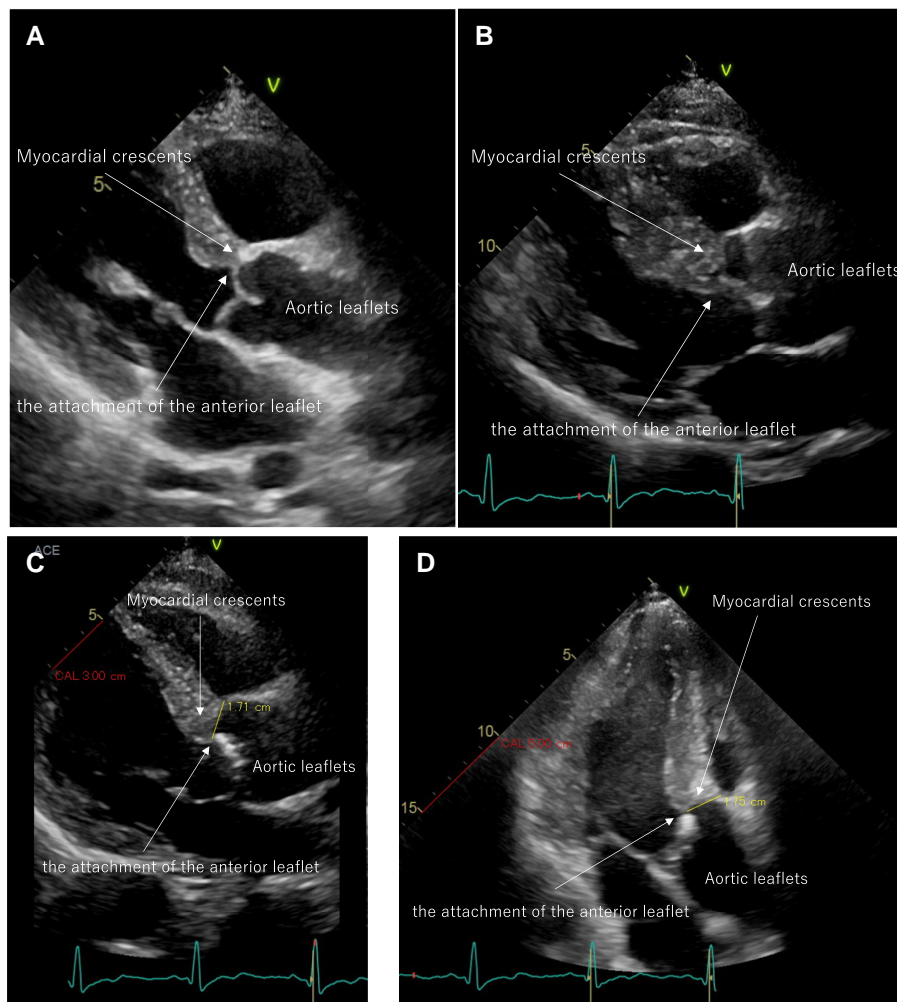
Trans-thoracic echocardiography. (A) Parasternal longitudinal view of a normal tricuspid aortic valve. (B) The conjoined leaflet originated from the inter-ventricular septum; the attachment of aortic leaflets was separated from the anatomical ventriculo-arterial junction and was displaced downwards into the left ventricle. (C) Parasternal longitudinal view showing that the width of the myocardium between the attachment of the leaflets and their supporting coronary sinuses was 17.1 mm. (D) Apical three-chamber view showing that the width of the myocardial crescent was 17.5 mm.
